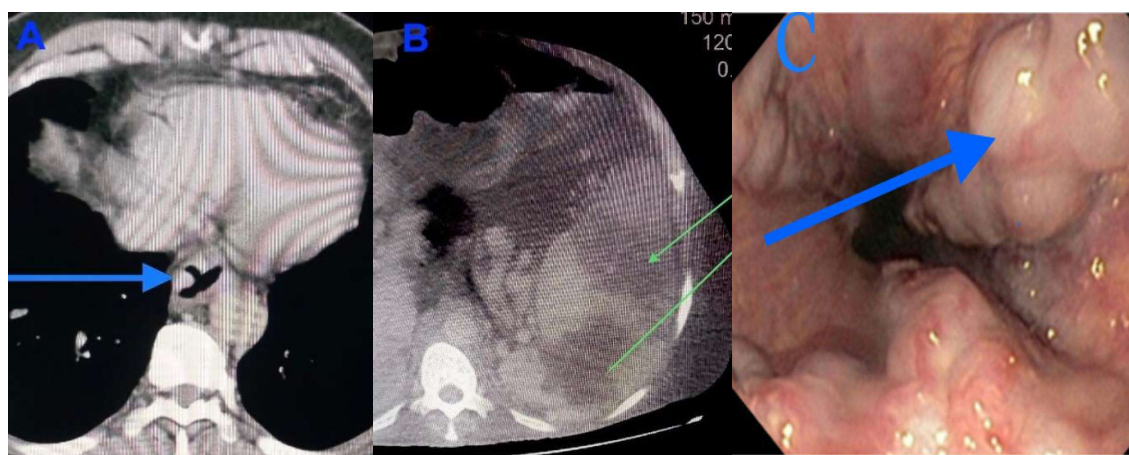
(A, B, C): 66 years old female patient with known liver cirrhosis presented with hematemesis. CT: Triphasic CT study portal phase of upper abdominal cuts portal phase shows few large well-defined high-risk varix score 4, the largest (blue arrow image A) measuring 7mm. Two large hypodense splenic focal lesions (green arrows in image B) were proven to be lymphoma as an accidental finding. Endoscopy findings: grade 3 esophageal varices(blue arrow image C).
